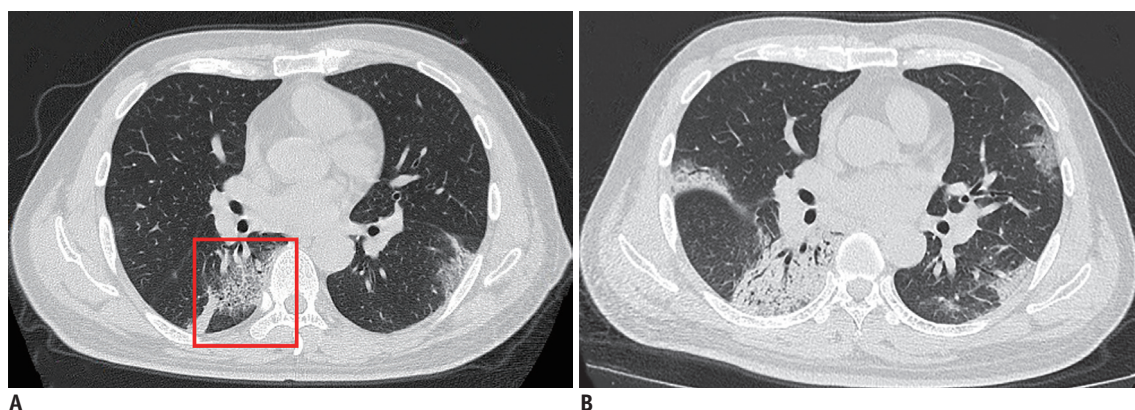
CT scans of 40-year-old male with COVID-19.
